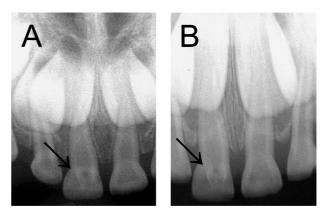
Periapical radiographs of maxillary primary incisor region (A) 3Y0M. (B) 5Y5M.
